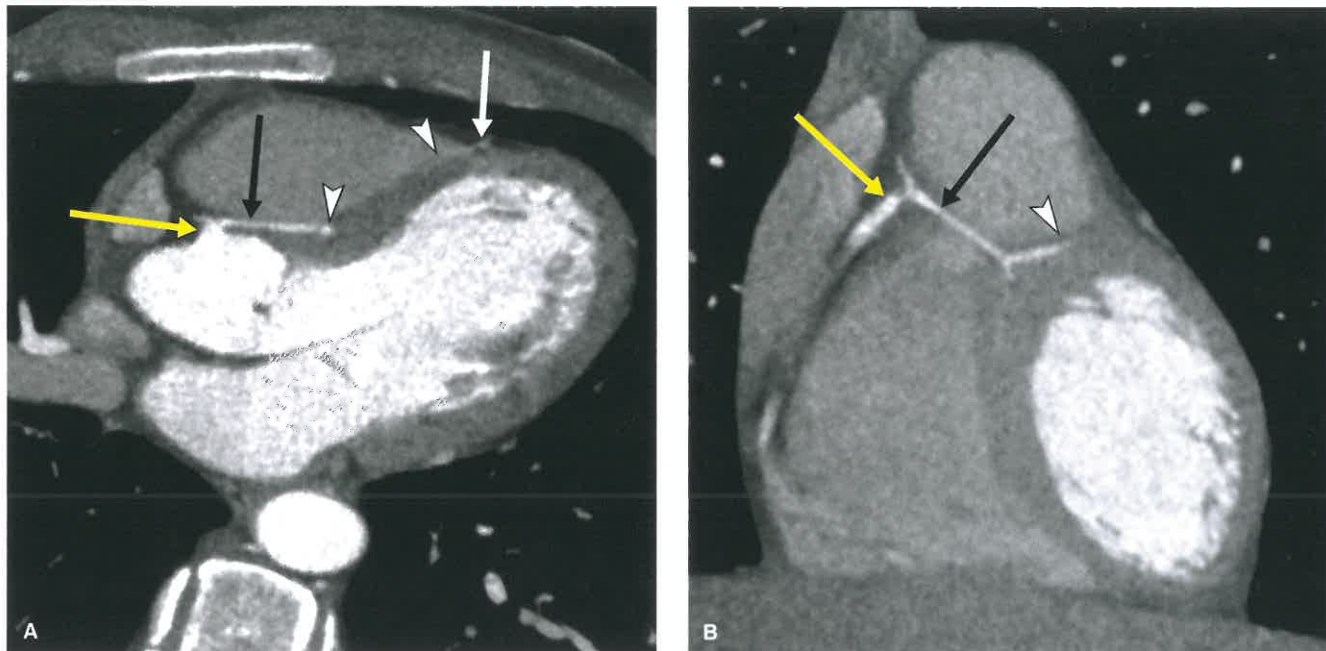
Septal Course of the Left Anterior Descending Coronary Artery (LAD). A: Axial oblique and (B) coronal oblique images from a coronary CTA show the LAD arising from the proximal RCA (yellow arrows) and coursing inferiorly and medially (black arrows) before diving into the interventricular septum (white arrowheads). The proximal and mid LAD (white arrowheads) run in the wall of the left ventricle consistent with a long-segment myocardial bridge. The distal LAD (white arrow) reenters its normal location in the epicardial fat. This benign course needs to be delineated from the potentially malignant interarterial course where the coronary artery crosses directly between the main pulmonary artery and aorta and does not have the inferiorly directed course as seen in this case.
